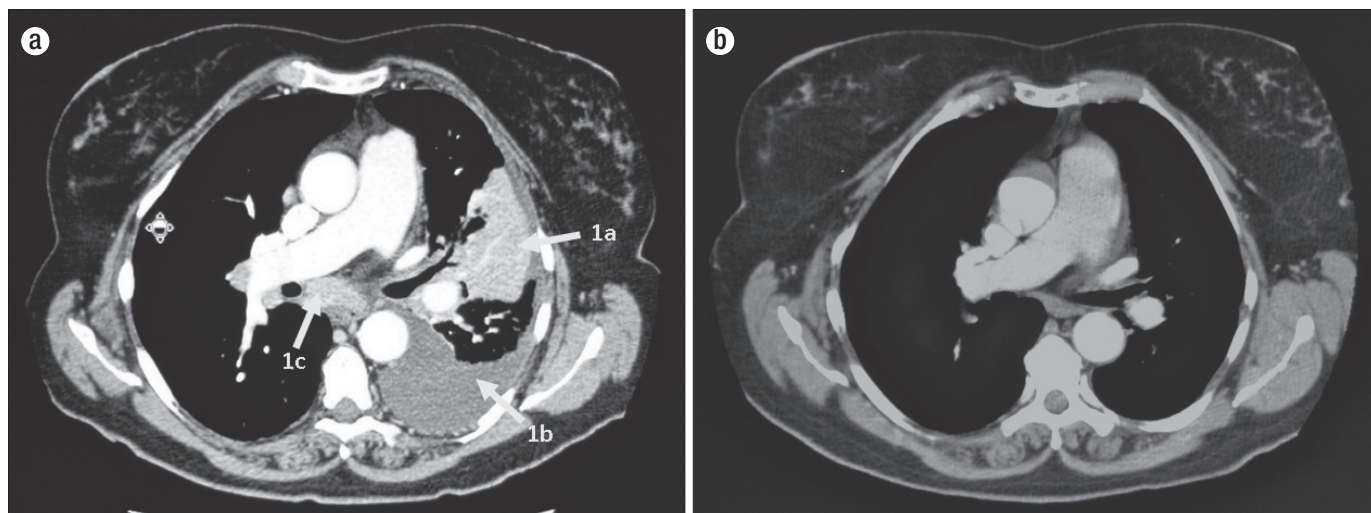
(a) The initial CT scan showing the left lung mass (1a), a pleural effusion (1b), and mediastinal adenopathy (1c). (b) The CT scan after 47 days of erlotinib showing near complete resolution of the pathologic findings.
